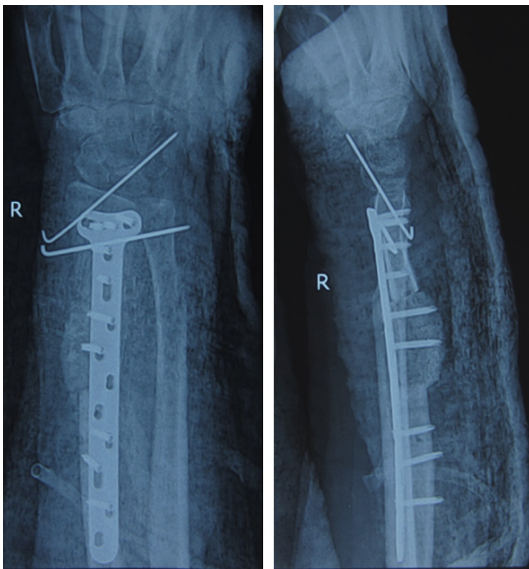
The typical pre- and post-operative X-ray representation of GCT of the distal radius. Immediately post-operative X-ray.
